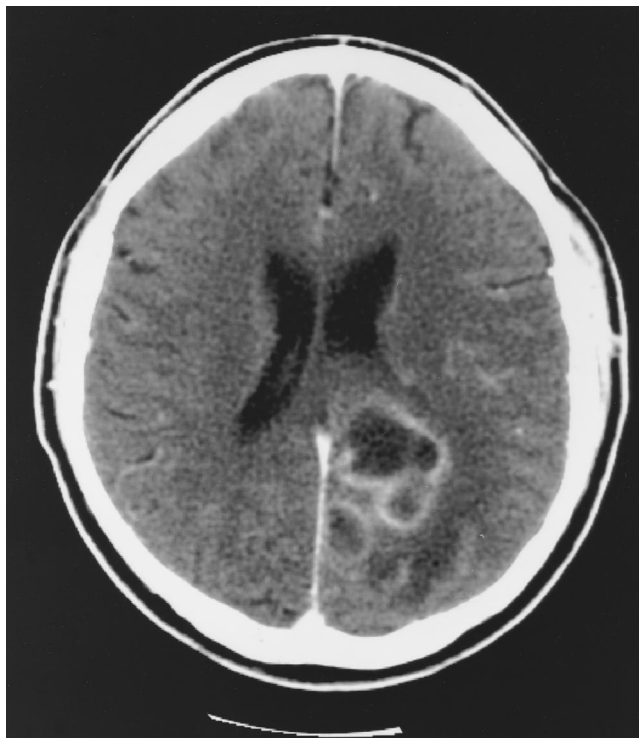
CT scan with intravenous contrast of the brain of a 47-year-old diabetic male who presented with headache and right-sided hemiparesis; an irregular 4.0 \times 5.0-cm ring-enhancing lesion is evident in the left occipital lobe, consistent with a brain abscess.
